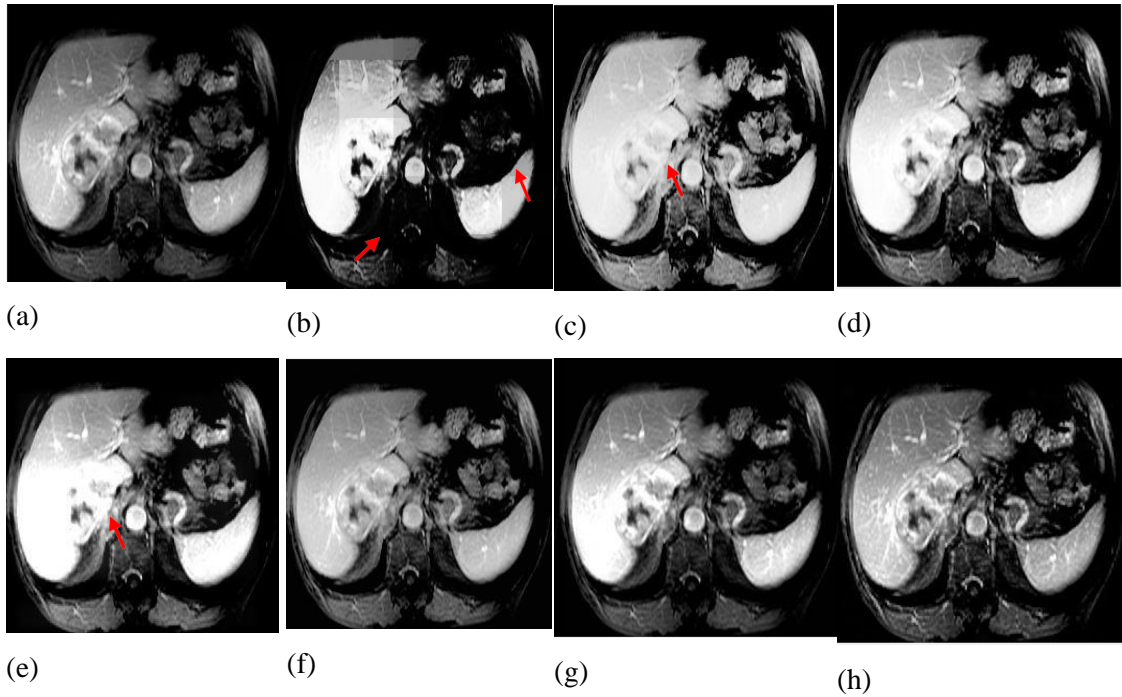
3.8. Input "CT-5" image and it's associated enhanced images (a) Input image, (b) S-curve, (c) AGC-DWT, (d) AGC-WHD, (e) GAGC-DWT, (f) EBCHE, (g) TCHE-DWT, (h) Proposed technique
